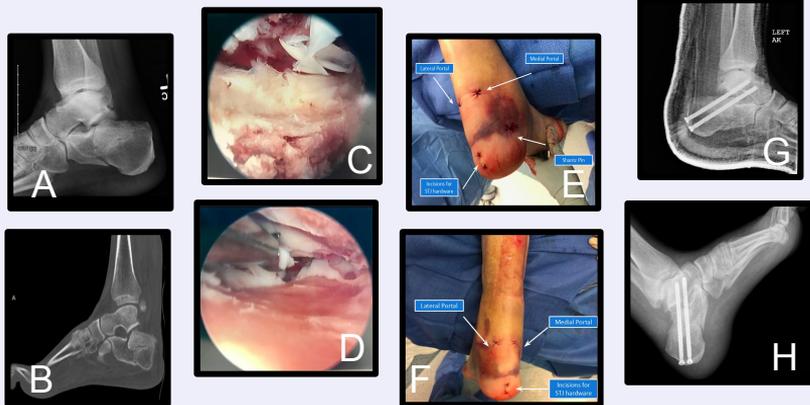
(A,B) Radiograph and CT imaging of intra-articular calcaneal fracture (C,D) Intraoperative arthroscopic images of fracture and arthrodesis site preparation (E-F) Portal sites and incisions (G) Postoperative radiograph (H) 6 weeks status post STJ fusion
